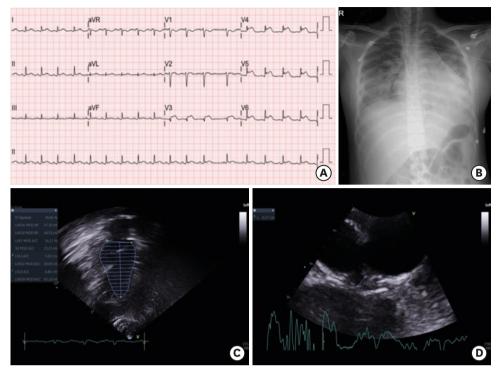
(A) ST elevation on leads V3–6 was detected on echocardiogram at first on hospital day 3. (B) In chest X-ray, cardiomegaly with marked pulmonary edema was shown on hospital day 4. (C) Echocardiography revealed marked left ventricle dysfunction and ejection fraction was checked 39% in biplane on hospital day 5. (D) Left main coronary artery dilatation of 5.7 mm (z-score 4.26) was detected on hospital day 6.
